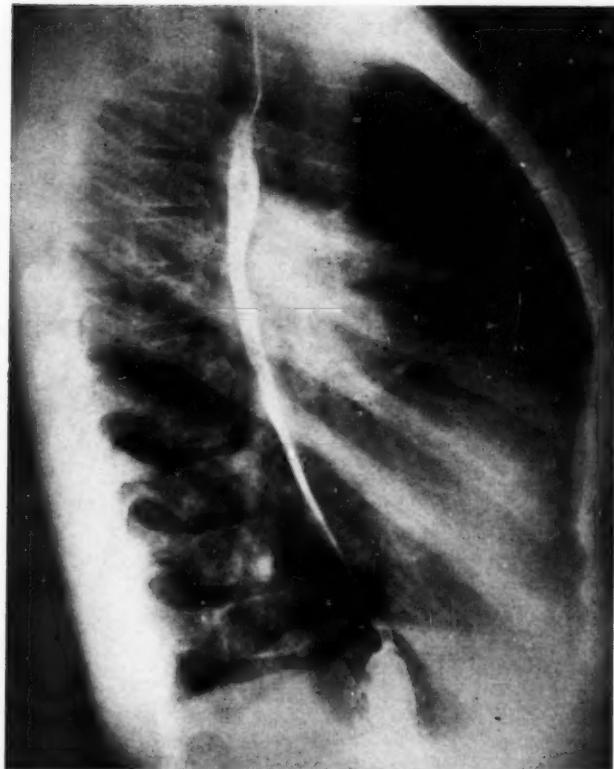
Lateral chest radiograph, showing marked right ventricular hypertrophy and absence of left atrial enlargement.
